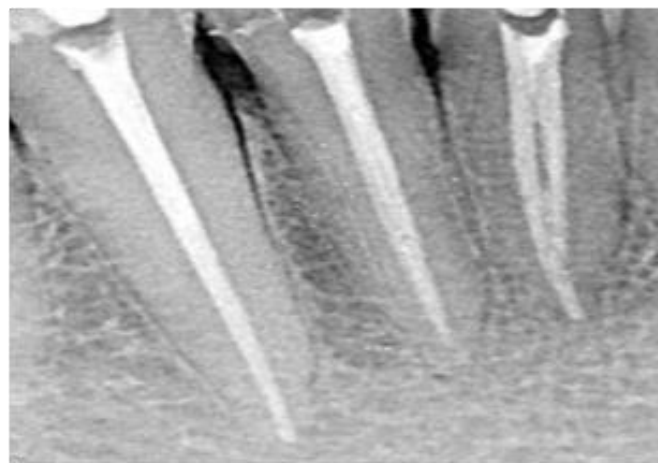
Obturation radiograph of 31, 32,33
